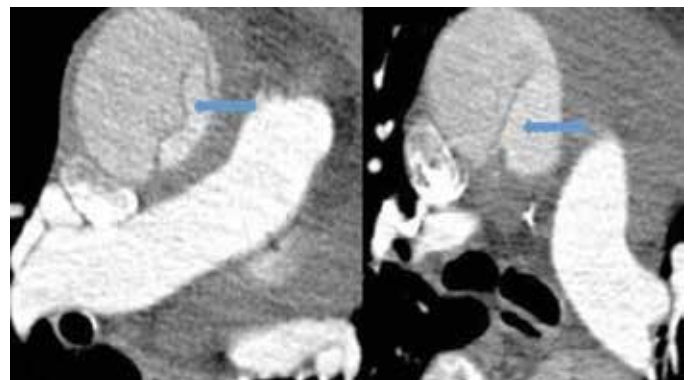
Aortic dissection of the second case seen in CT angiography
